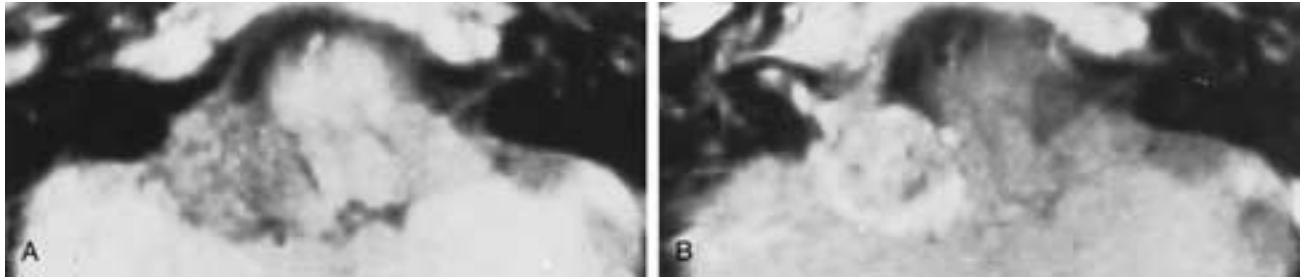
CPA choroid plexus papilloma. A and B, T1-weighted pre- and postgadolinium images. The tumor is located at the foramen of Luschka, as in [Figure 25-50](#). It is well demarcated from the brain. Enhancement is mild and inhomogeneous. The specks, which are hypointense on both images, suggest calcifications. (Courtesy of Dr. Val M. Runge.)
